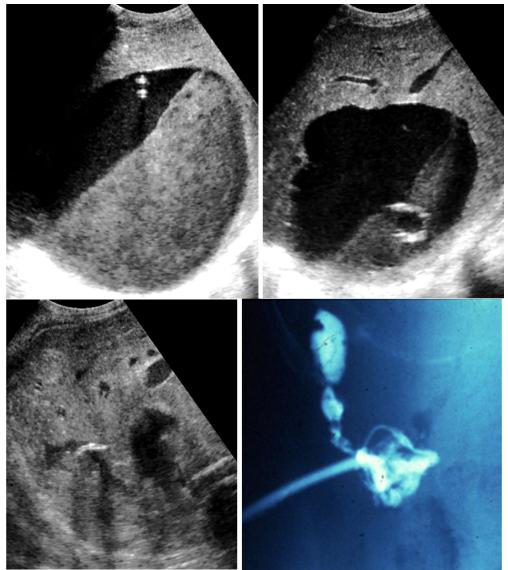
a-d Puncture sonographic (and clinical) liver abscess; SCS diagonal (c and d after sonography guided puncture and drainage)
